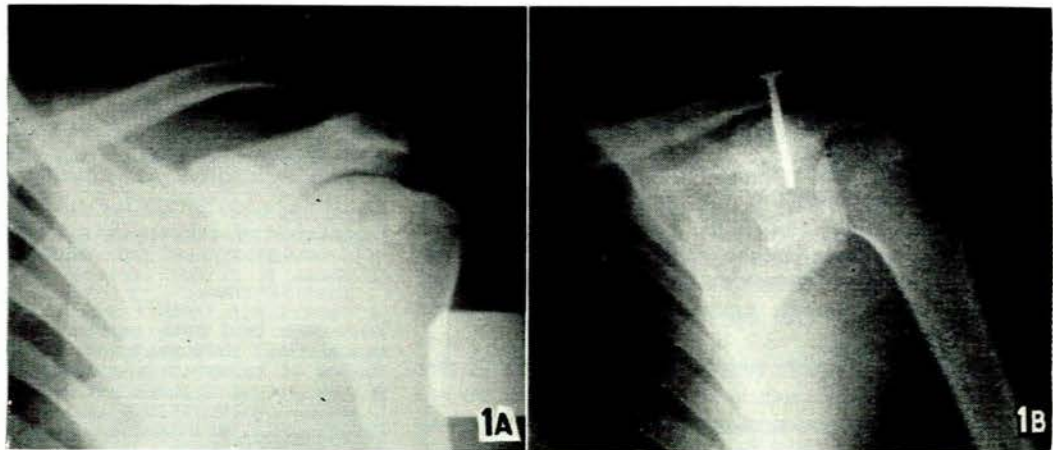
X-ray plates of acromioclavicular dislocation in a Bantu labourer. A. Pre-operative view. B. Postoperative view.
